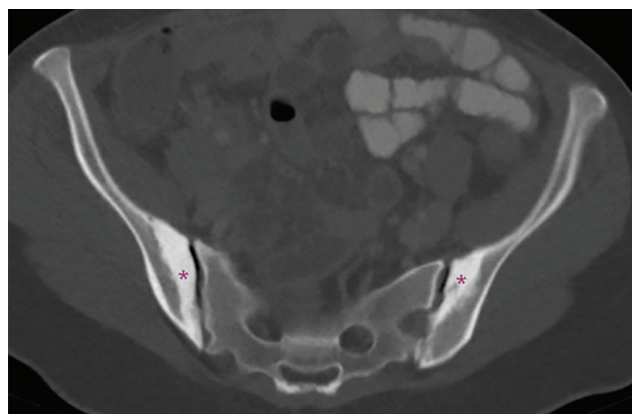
Computed tomography image from patient's evaluation for colitis. This axial view of the midsection of the sacroiliac joints shows bilateral subchondral sclerosis predominant on the iliac sides (asterisks), findings consistent with osteitis condensans ilii.
